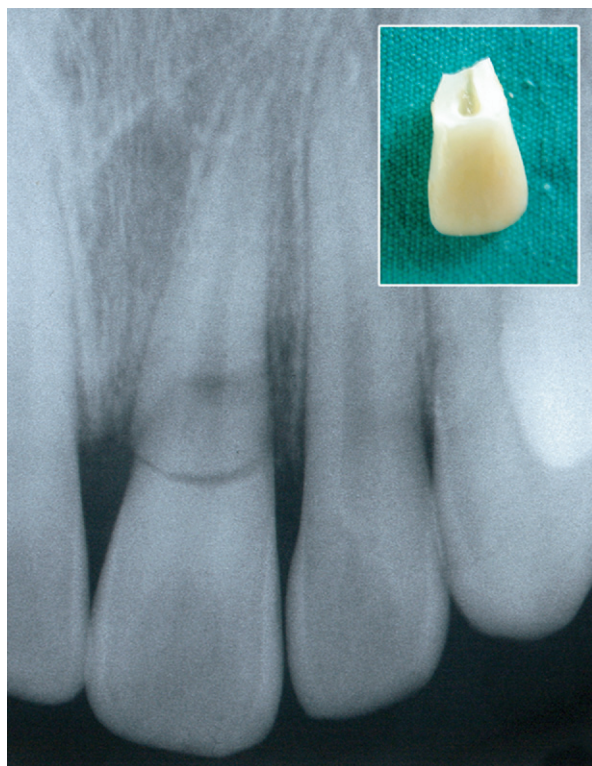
Radiographic view of the traumatized incisor, revealing borders of the oblique crown-root fracture. The extracted coronal fragment (*upper right*) confirms the radiographic extent of fracture.
